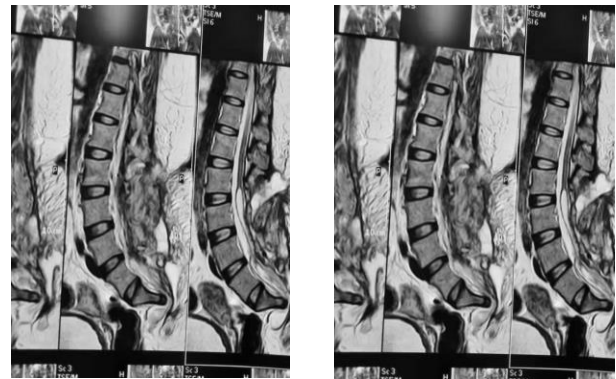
Post-operative MRI T1 and T2 sagittal view showing operative site from L2 to the sacrum and decrease in the size of the intradural lesion and the anterior meningocele.
